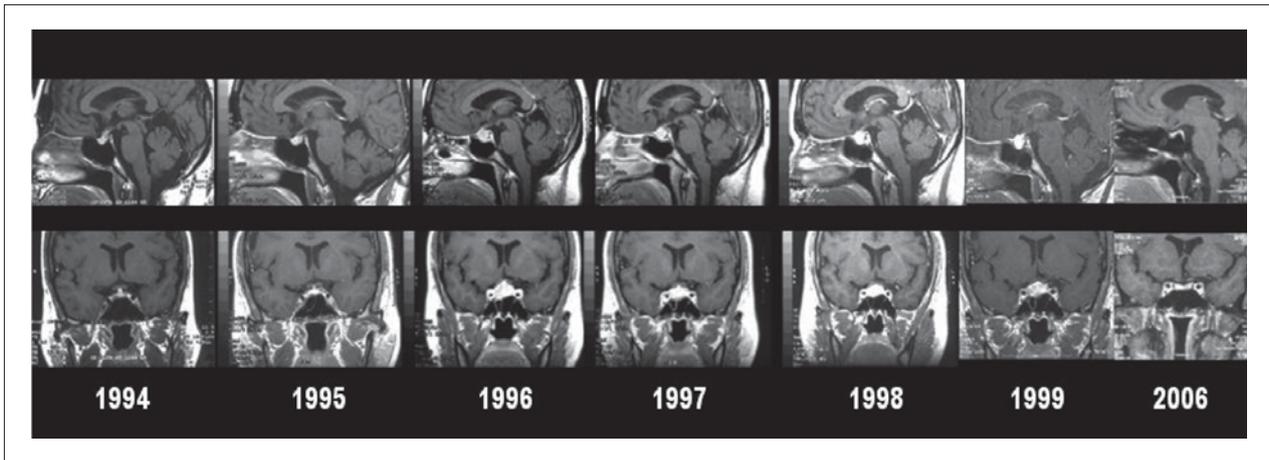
Serial MRI scans over time demonstrating a thickened pituitary stalk that evolved into a pituitary mass that progressively reduced in size leading to final disappearance of the mass.
